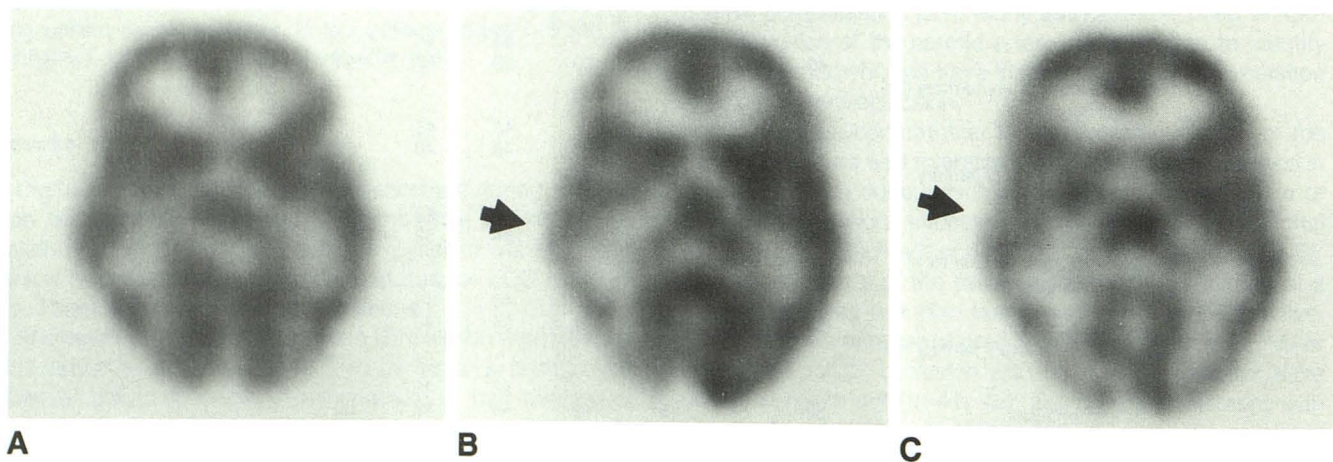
SPECT images in case 8. Arrows indicate areas of hypoperfusion on side of internal carotid occlusion.
